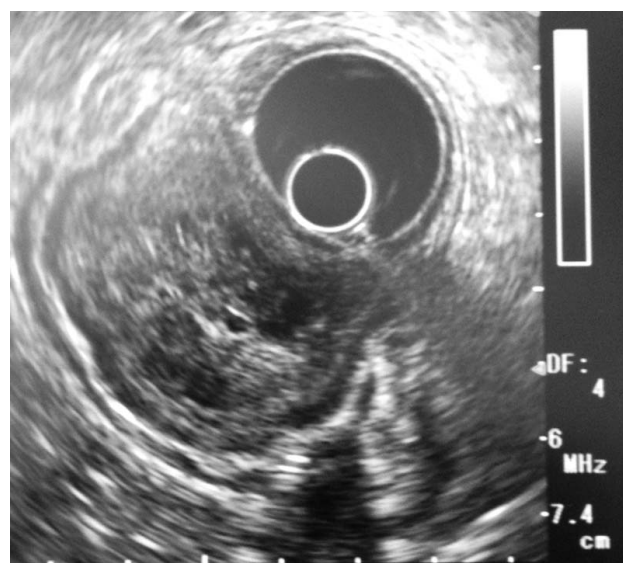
Endoscopic ultrasonography reveals a tumor with complex low and high echogenicity located in the submucosal and muscle layers (third to fourth layers).
